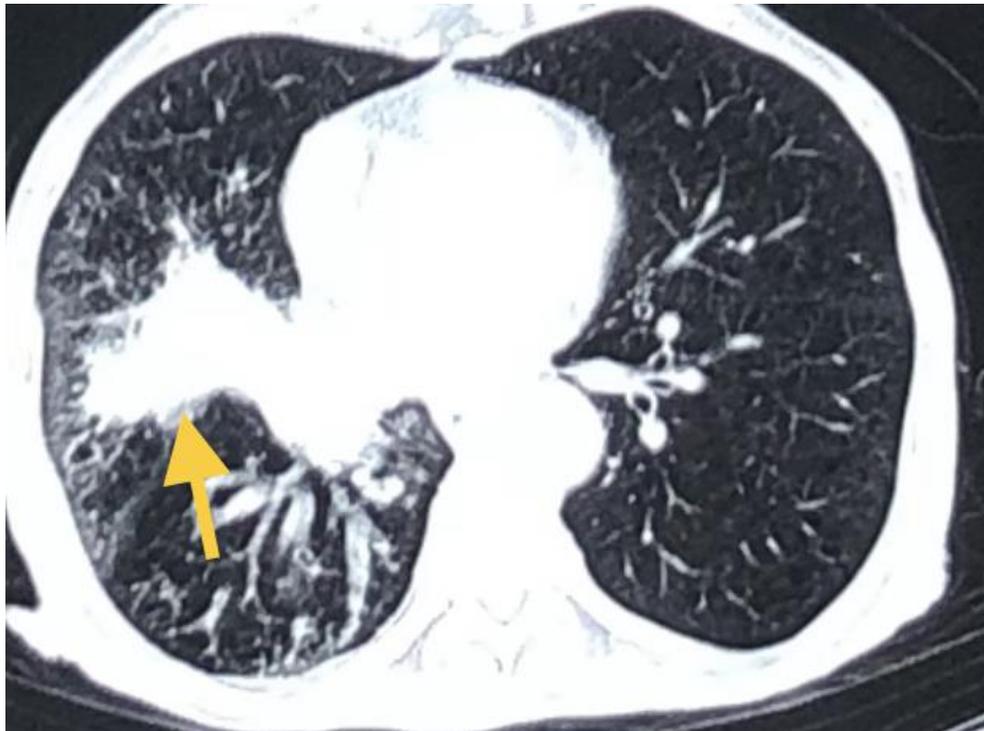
An elderly male with recent COVID-19 infection, chest CT reveals bilateral diffuse emphysematous changes (yellow arrow shows Right sided emphysematous bullae), and small Right sided subpleural nodule (red arrow) suggestive of malignant process.
